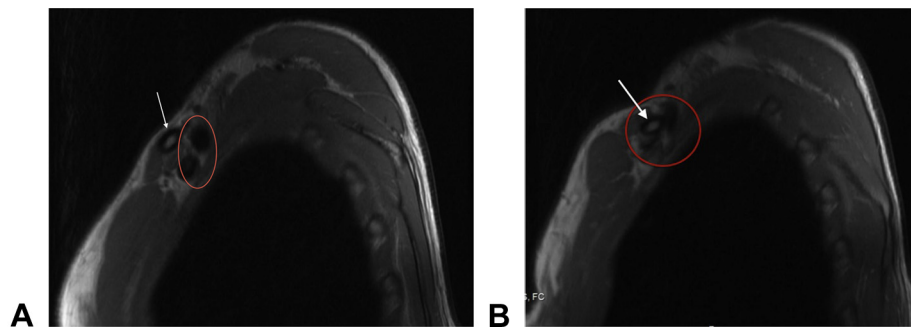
A Magnetic resonance image with shoulder in neutral position indicates adequate space for the subclavian vessels (oval) behind the clavicle (arrow). B When the arm is abducted, the costoclavicular space (circle) is significantly diminished with evident compression of the vessels.
